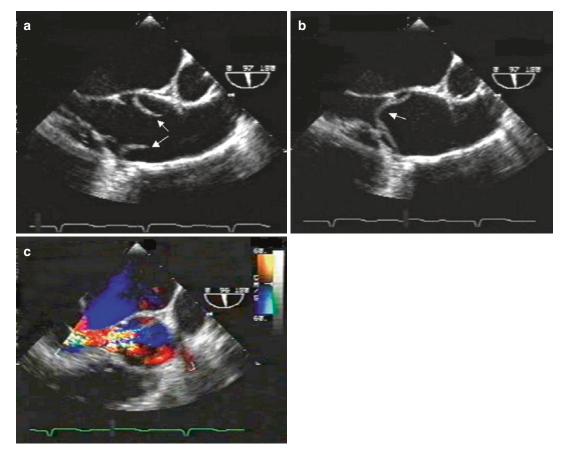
Transesophageal echo long-axis image of an ascending aortic dissection, with intimal flap (arrows) prolapsing into the aortic valve; (a) systolic image; (b)
